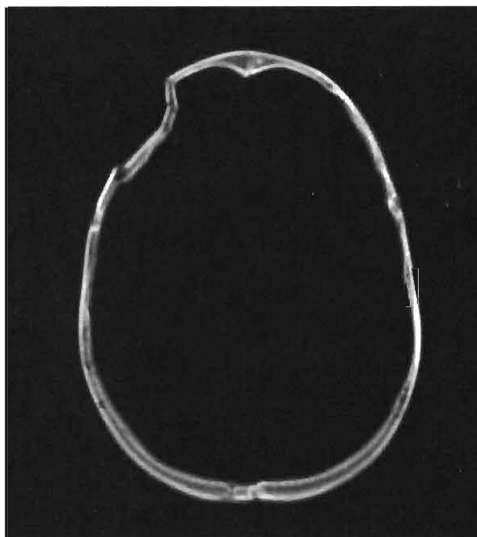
Right frontal depressed skull fracture caused by an assault with a hammer (axial CT scan, bone window).
